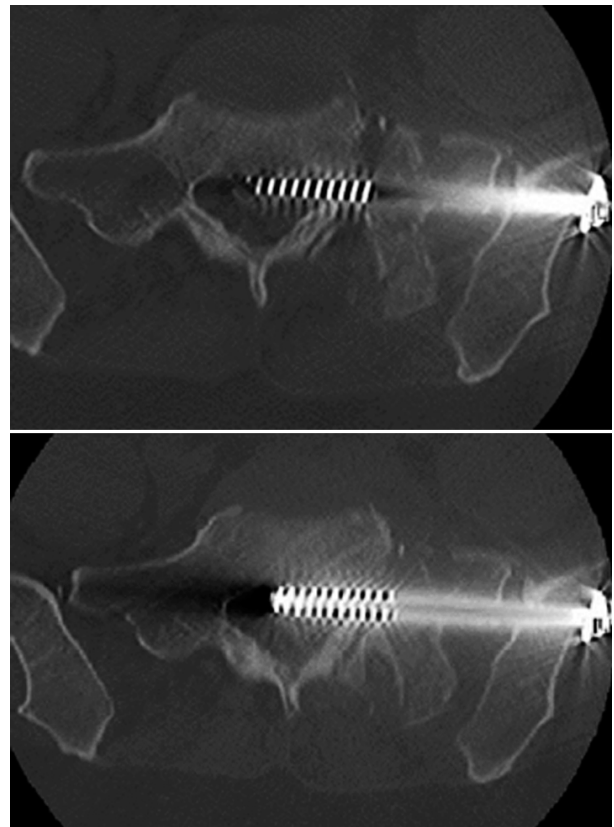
Axial CT scan of spinal canal showing the iliosacral screws breaching the integrity of the spinal canal.
